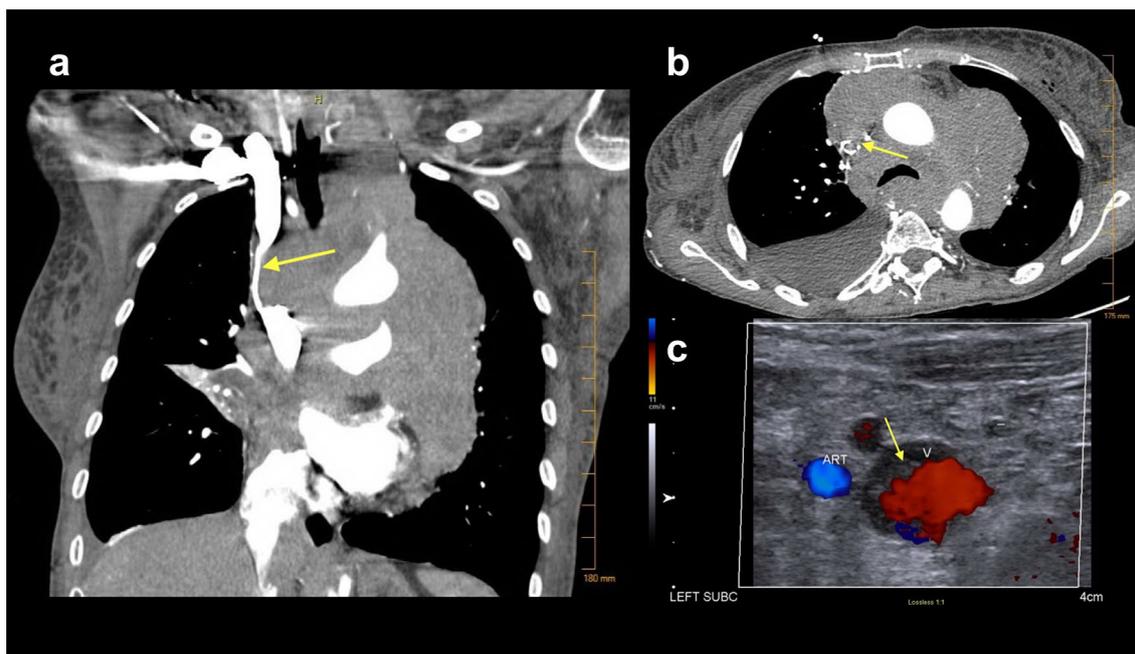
a Coronal plane and b axial plane of the computed tomography of the chest showing a massive mediastinal and hilar lymphadenopathy producing high-grade stenosis of the superior vena cava
